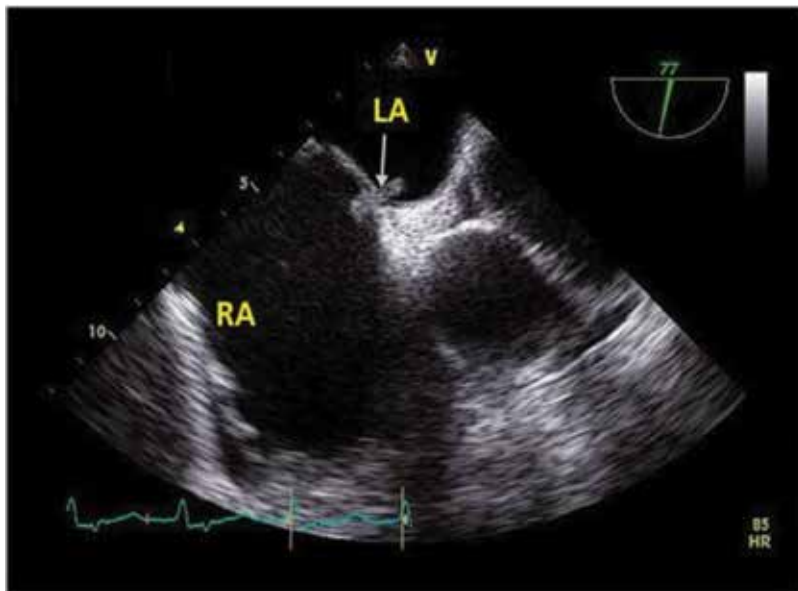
Echocardiogram demonstrating thrombus in transit across PFO.
